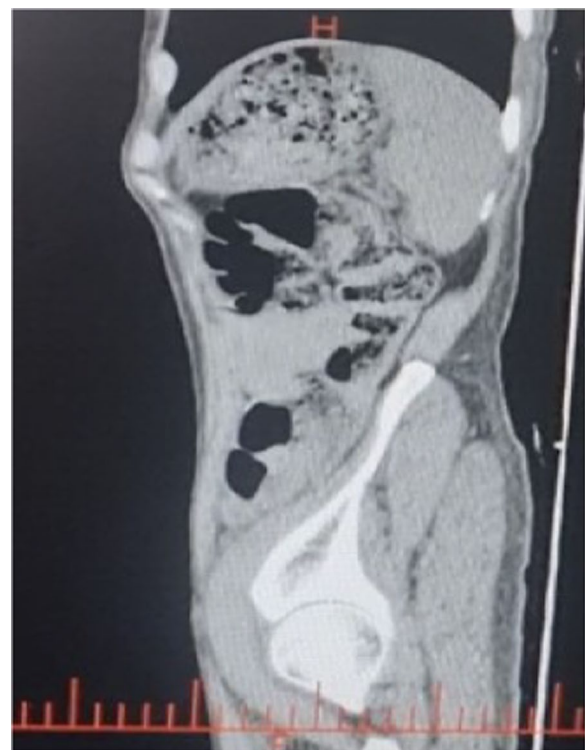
Computed tomography scan revealed an image of ileus and intramural gas in the small intestine
